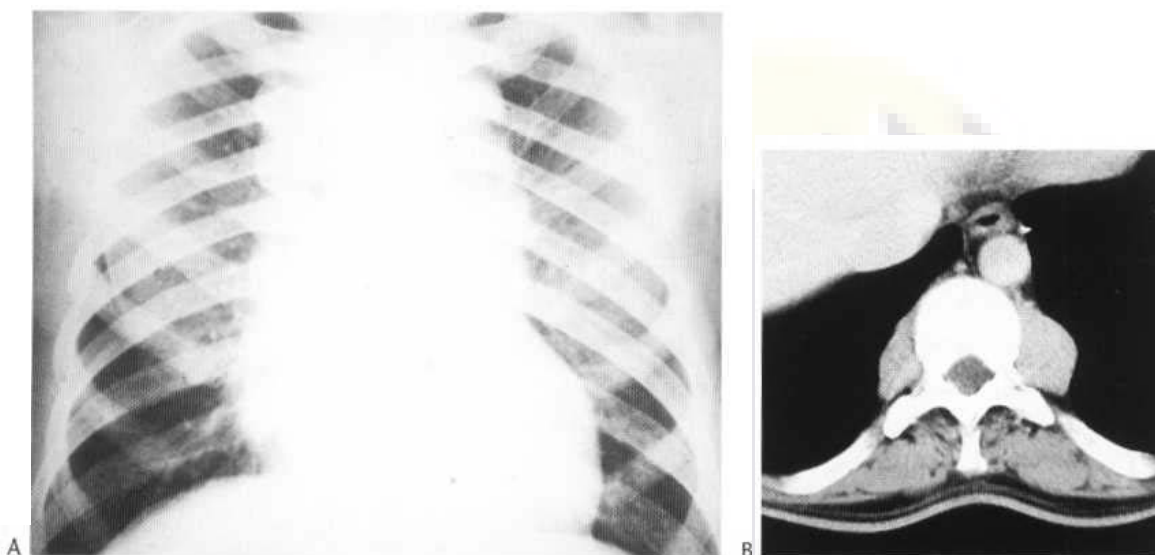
Thalassaemia. (A) Lobulated soft-tissue masses due to extramedullary haematopoiesis are present adjacent to the thoracic spine. (B) In another patient, paravertebral extramedullary haematopoietic tissue is shown in the lower sections of a CT examination of the thorax.
